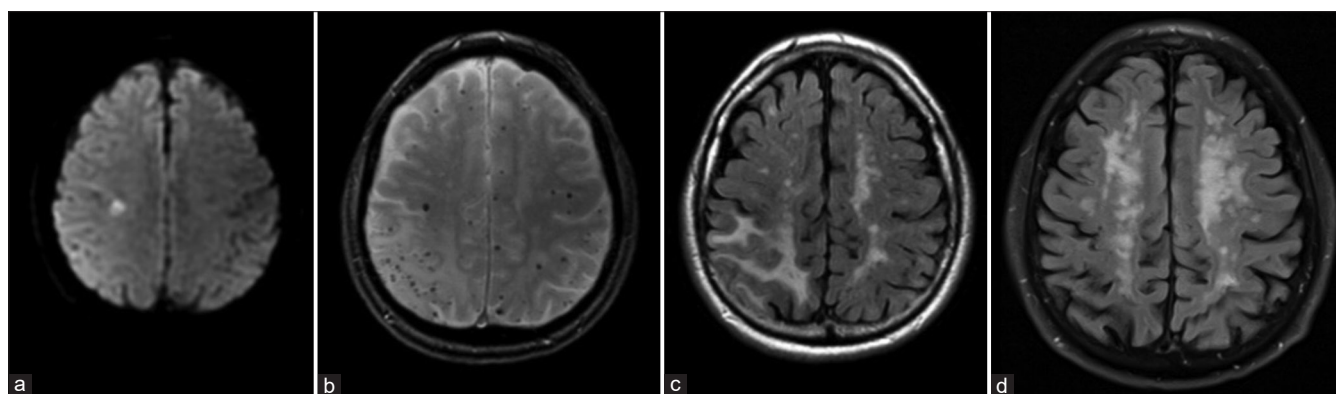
MRI brain with and without contrast of a 69-year-old male with CAA-RI before and after corticosteroid therapy. (a-c) Initial brain MRI. Diffusion-weighted imaging with right frontal infarct. (a) Gradient echo imaging demonstrated multifocal cerebral microbleeds with predominance in the right parietal lobe. (b) T2-FLAIR sequence with asymmetric white matter hyperintensities with predominance in the right parietal lobe and background moderate burden of chronic microvascular disease. (c) Repeat imaging with resolution of right parietal white matter hyperintensities with the progression of chronic microvascular disease. (d) Repeat brain MRI 2 months after initial presentation and corticosteroid therapy. MRI: Magnetic resonance imaging, CAA-RI: Cerebral amyloid angiopathy-related inflammation, FLAIR: Fluid-attenuated inversion recovery.
